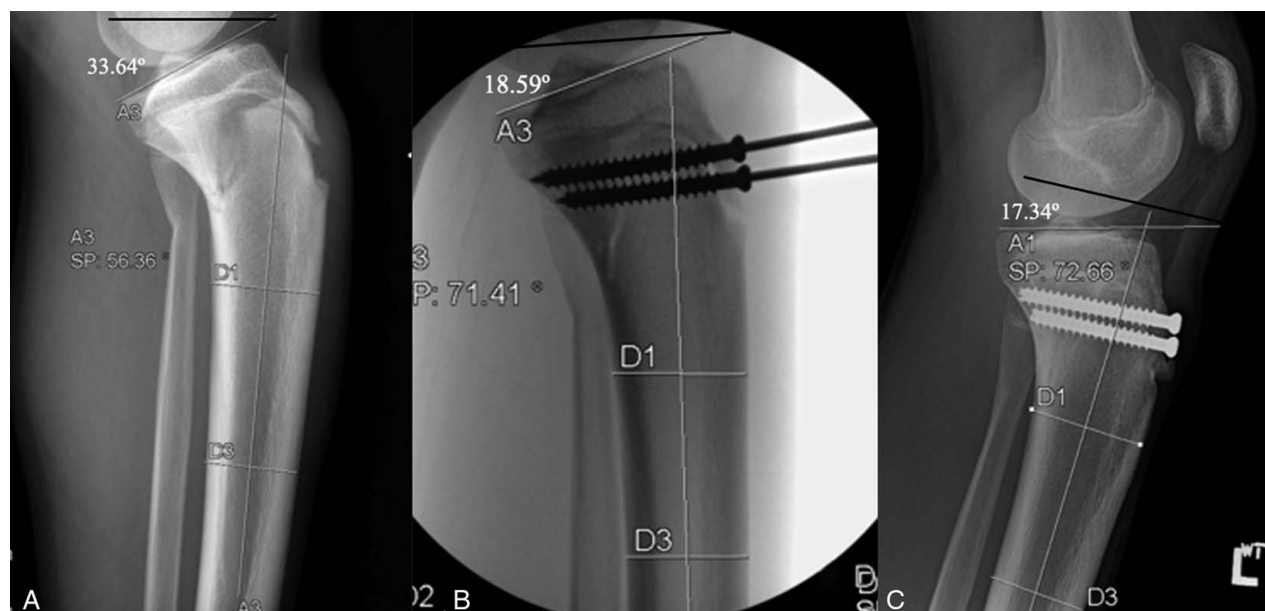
A 14-year-old male with type IV tibial tubercle fracture. A, Initial injury. B, Intraoperative lateral demonstrates improvement in posterior tibial slope angle. C, Follow-up radiograph 3 months postoperative.
